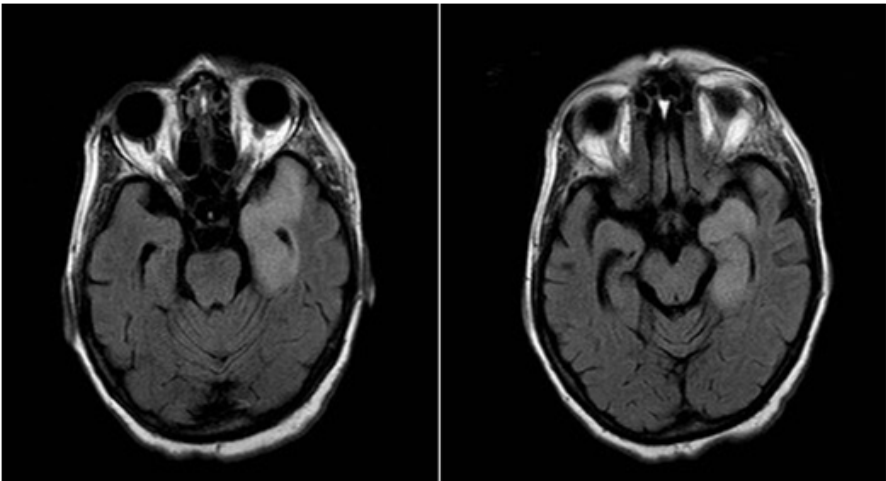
Asymmetrical increased signal intensity in the medial surface of the temporal lobe on the left hemisphere on axial Fluid-Attenuated Inversion Recovery (FLAIR) images.
